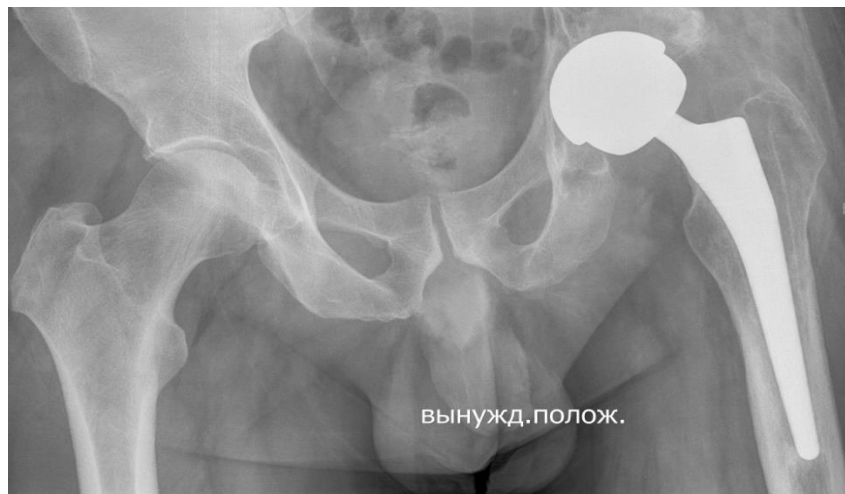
Plain radiograph of the pelvis before surgery.
